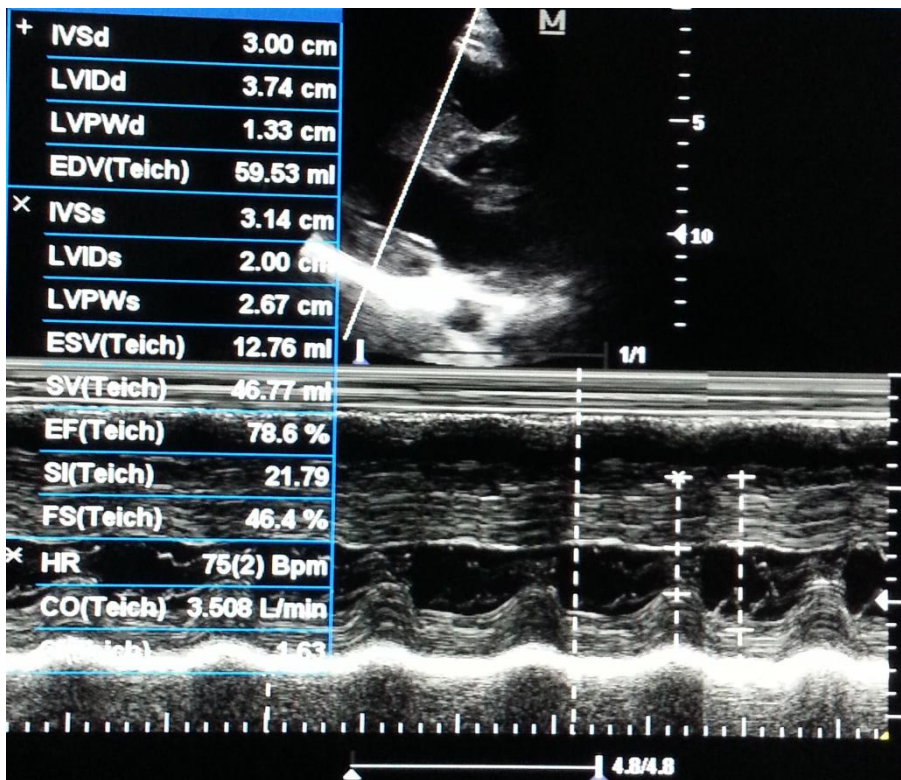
2D guided M mode echocardiogram revealed grossly hypertrophied left ventricle with asymmetric septal hypertrophy (ASH) and small LV cavity.
